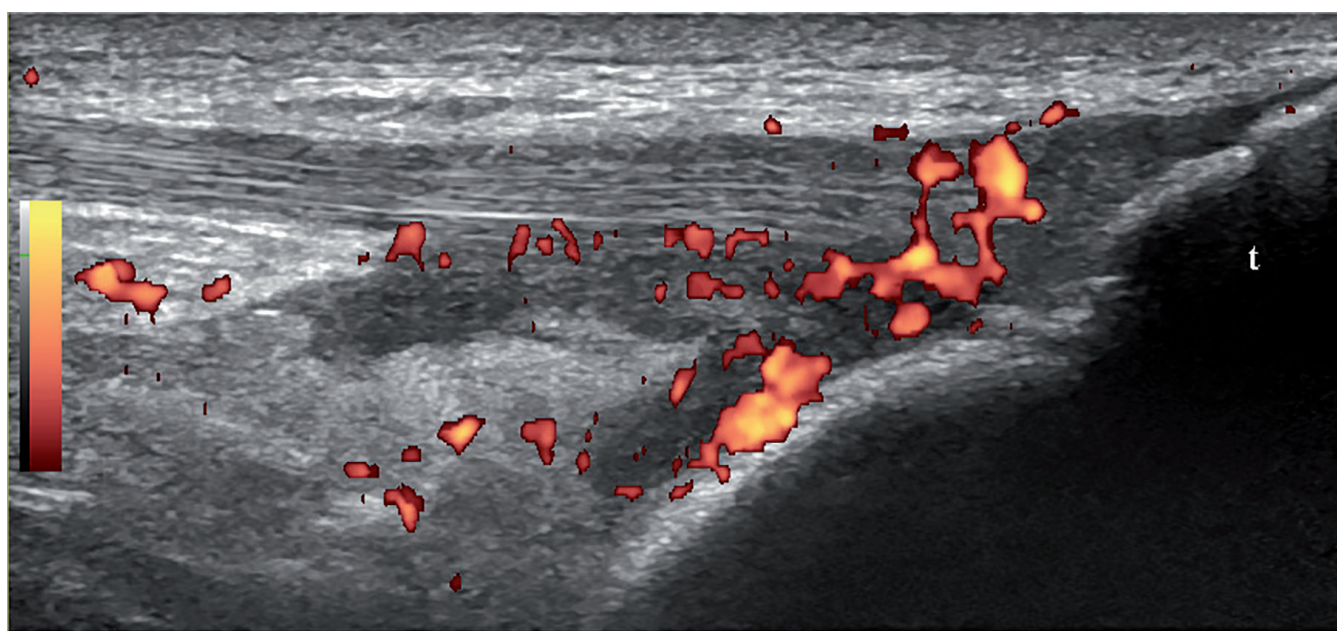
Longitudinal ultrasound image of the patellar tendon that shows grey-scale distal enthesopathy and deep infrapatellar bursitis with power Doppler signal in a patient with psoriatic arthritis. t: tibia.
